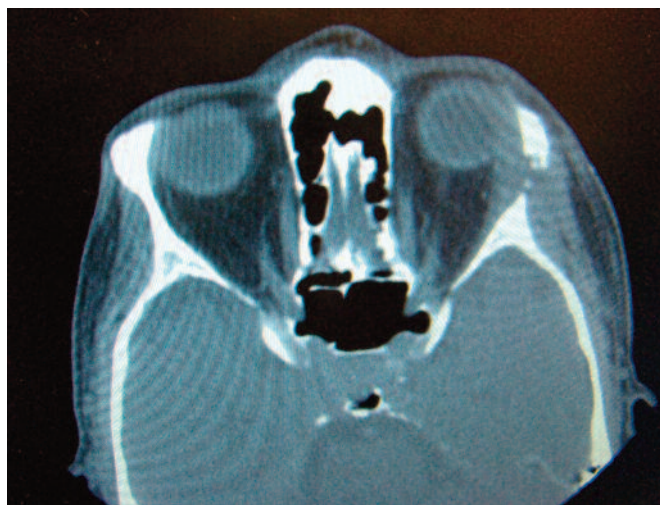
CT scan showing fullness of left temporal fossa with erosion of lateral orbital bone by soft tissue mass.
